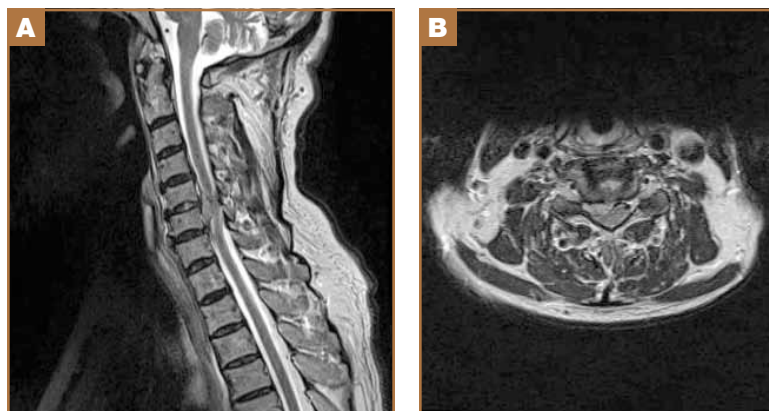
Representative (A) T2-weighted sagittal and (B) T2-weighted axial magnetic resonance images at 5-week follow-up. Extruded disc is stable in appearance and size compared with initial presentation, measuring 12 mm transversely by 7 mm anterior-posteriorly by 23 mm craniocaudally.
